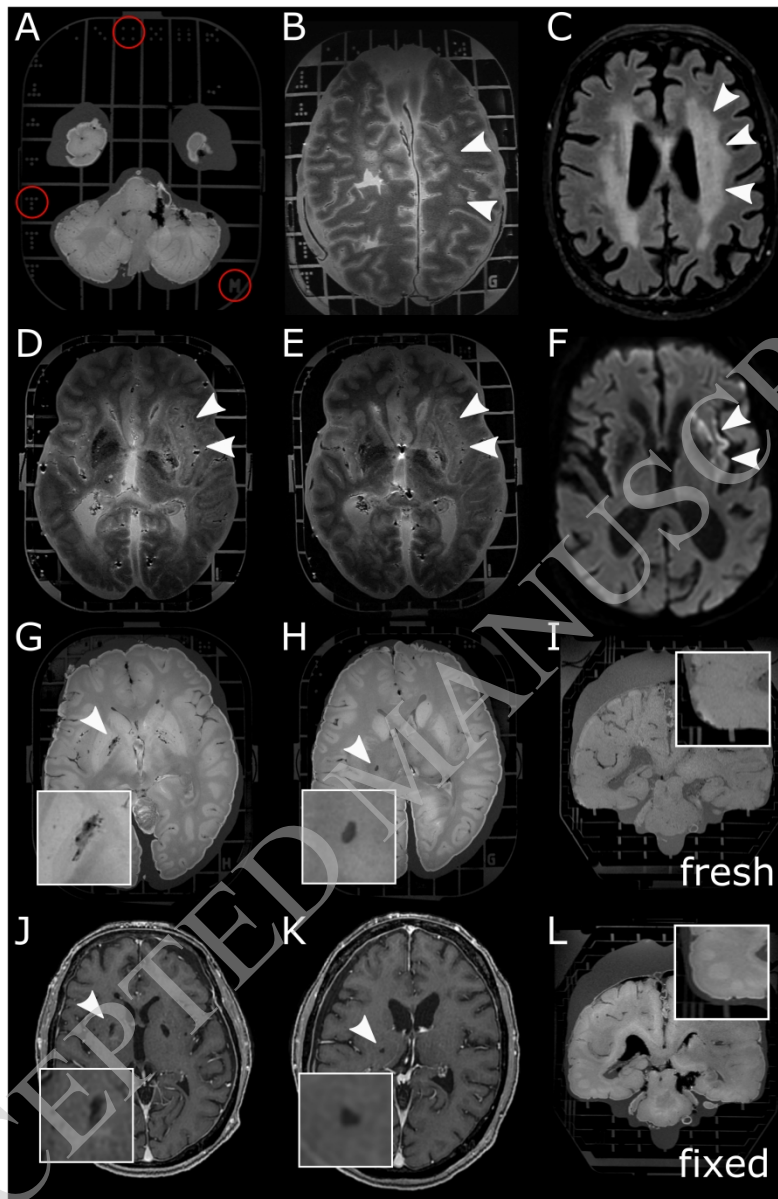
Whole-brain MRI using the Brainbox:
